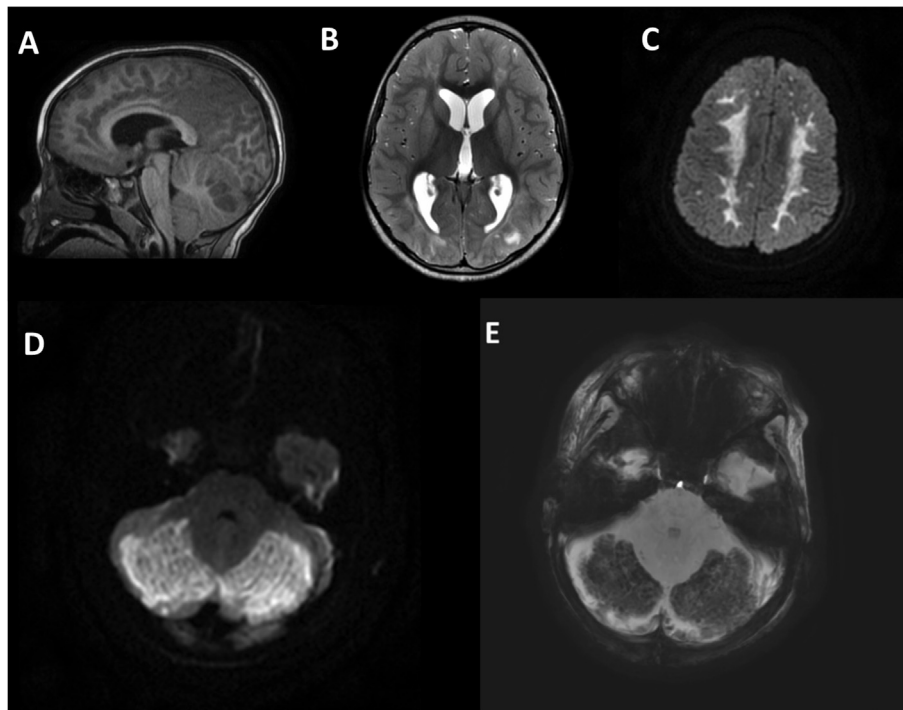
Pre-operative MRI. A) Sagittal T1-weighted image showing brainstem compression, B) Axial T2-weighted image showing hydrocephalus, C) Axial DWI showing supratentorial white matter changes, D) Axial DWI showing infratentorial white matter changes, E) Axial gradient echo image showing hemorrhagic conversion.
